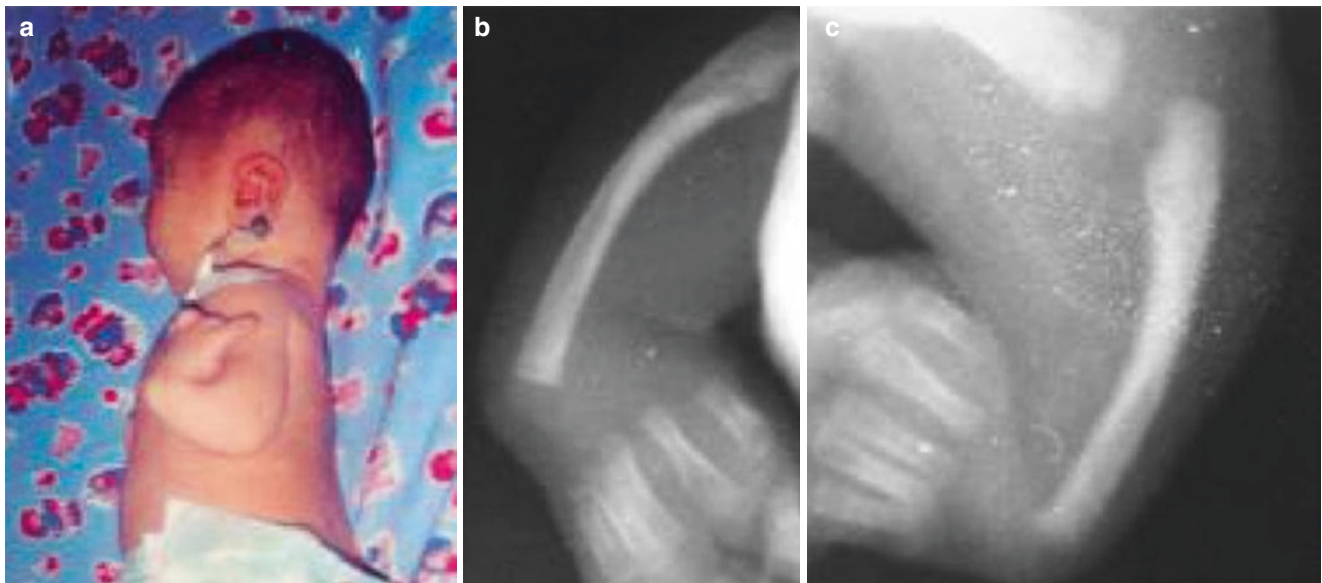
Thrombocytopenia-absent radius syndrome. (a) Deformed appearance. (b, c) X-ray findings (Originate from Pavlenishvili IV. Thrombocytopenia-absent radius - TAR-syndrome. Georgian
